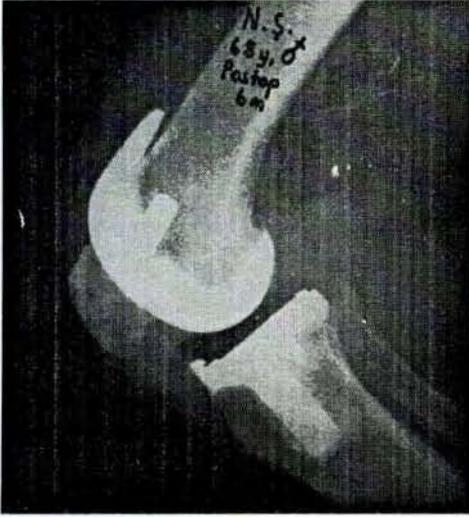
b: Postoperative 6th month 90° flexion lateral X-ray
